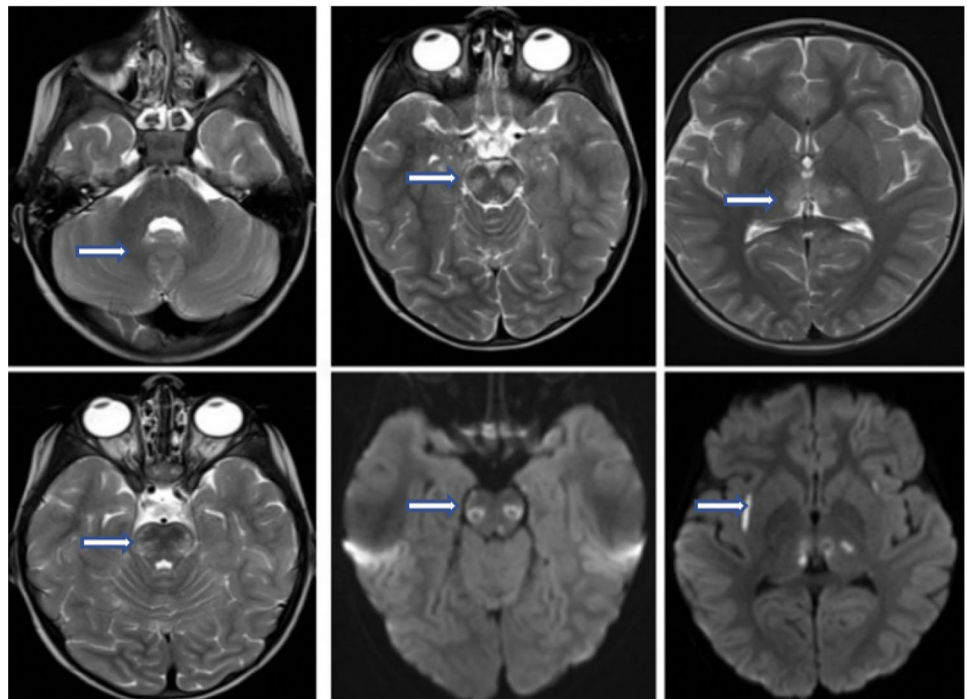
T2- and Flair-weighted images and diffusion MRI of the patient 7. There are extensive signal increases in the bilateral thalamus, external capsule, mesencephalon, pons, and mammillary body.
